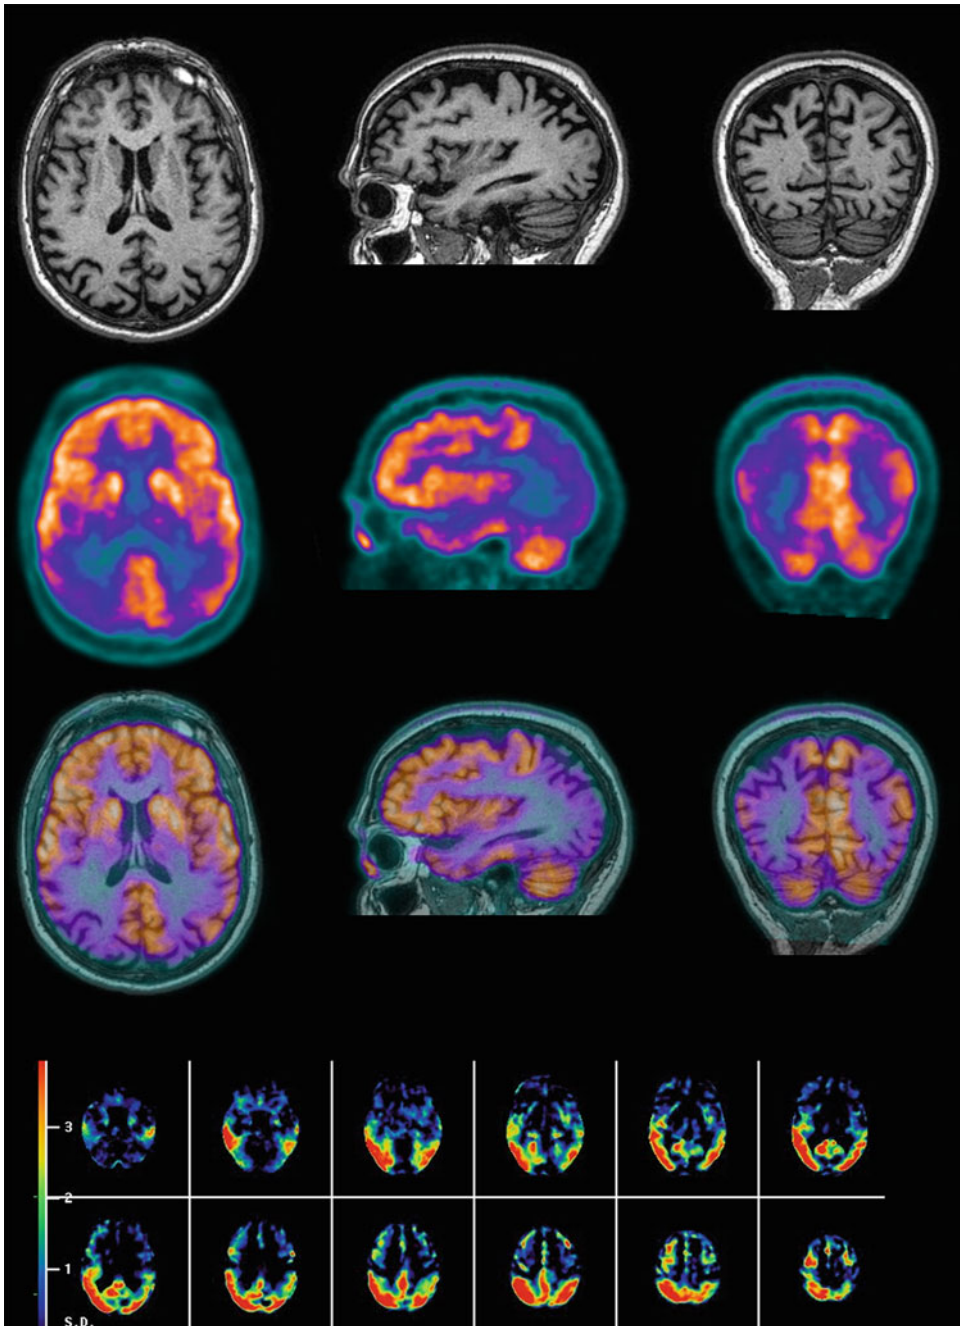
T1w 3D MR images (first row), FDG PET images (second row), and fused PET-MRI images (third row) in a patient with a clinical diagnosis of PCA, showing an atrophy in parieto-occipital cortex and a more extensive parieto-occipital hypometabolism.
